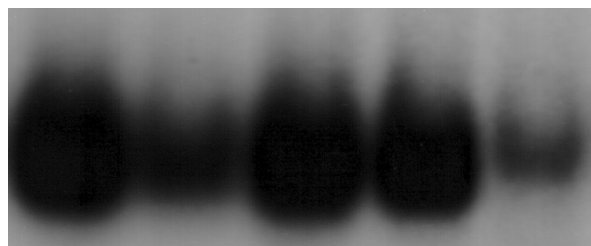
Representative radiographs of HSF-1 activation in PBMCs of patients with acute pancreatitis. Lanes 1-5.
